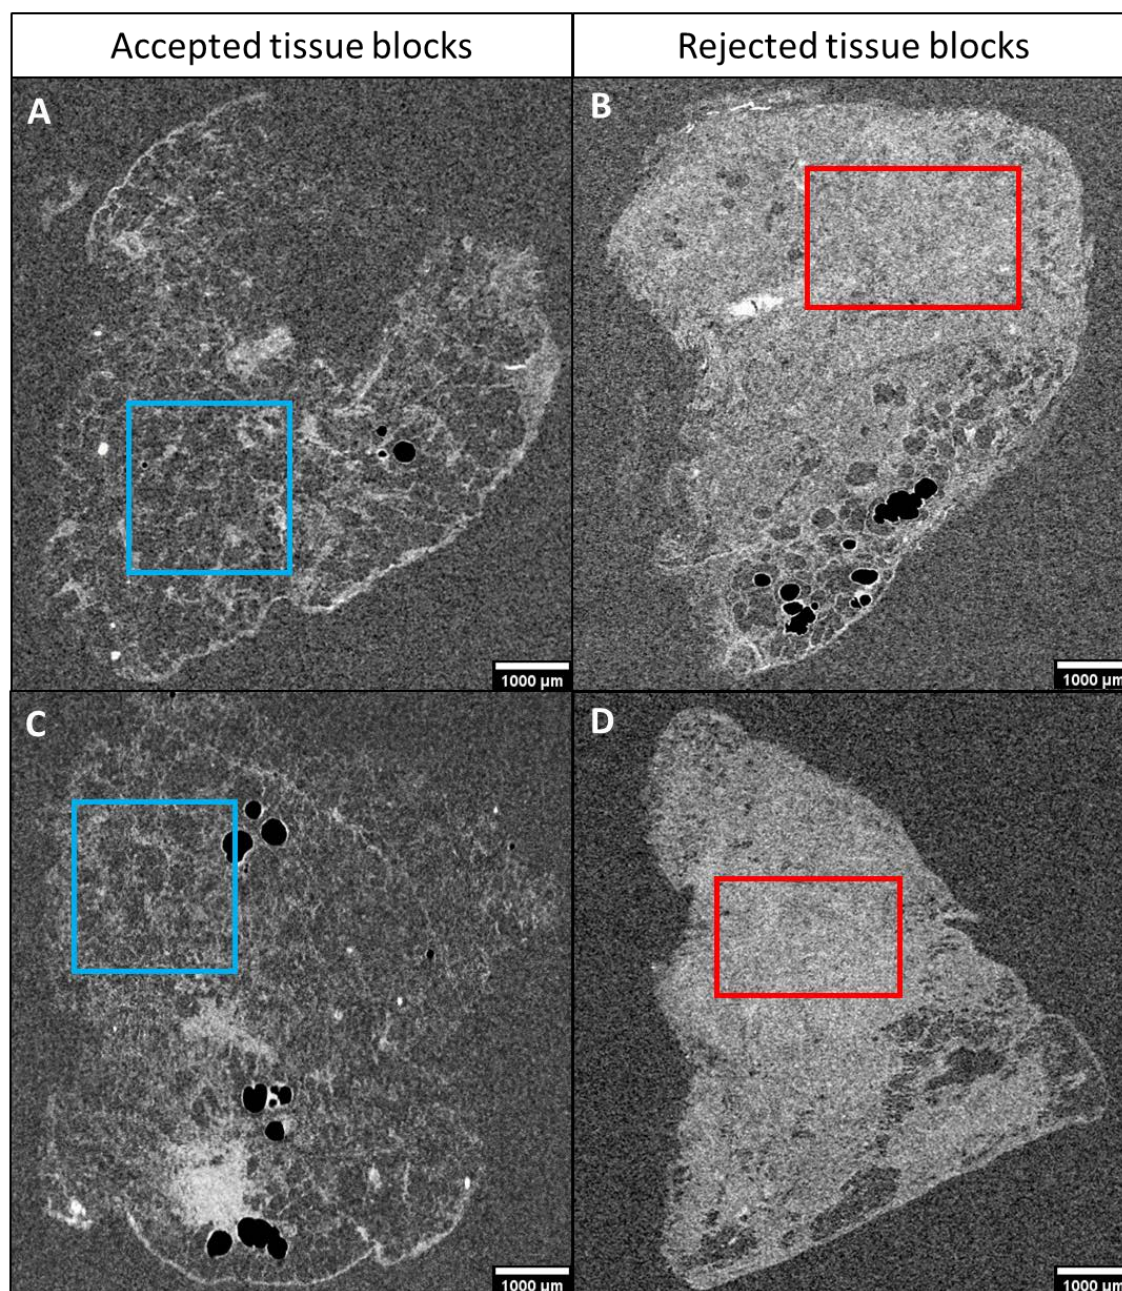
Exemplar reconstructed 2D slices from the quick  $\mu$ CT scans (<20 min) used for sample selection. A & C: Two  $\mu$ CT slices of tissue blocks which met the inclusion criteria, 'normal' lung structure (parenchyma) which was a key part of the inclusion criteria is highlighted by the blue box. B & D: Two reconstructed slices of tissue blocks which did not meet the inclusion criteria, the red boxes show homogenous areas of tissue lacking structural features which did not meet the inclusion criteria.
